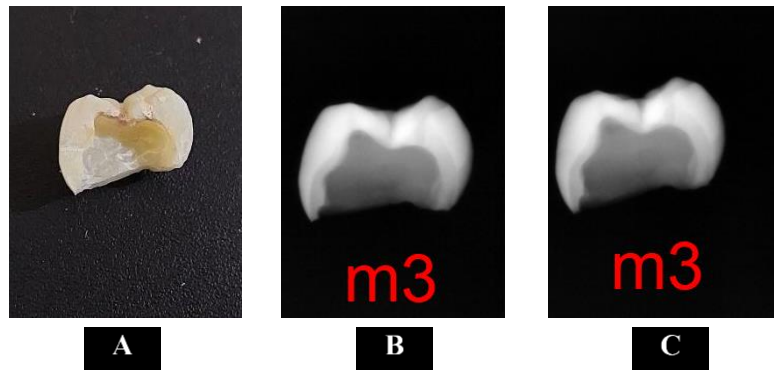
Sample with 40 Gy Irradiation (A) Clinical photograph, Radiograph Image of pre-irradiated Tooth Enamel of Molar and (C) post-irradiated
